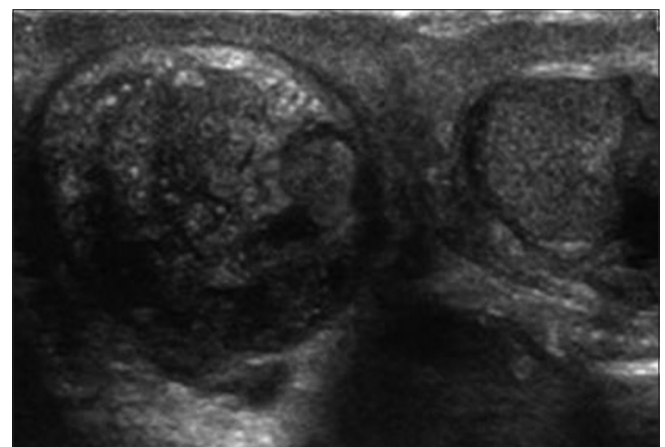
In Case 3, ultrasonography scrotum showing smaller and avascular left testis
